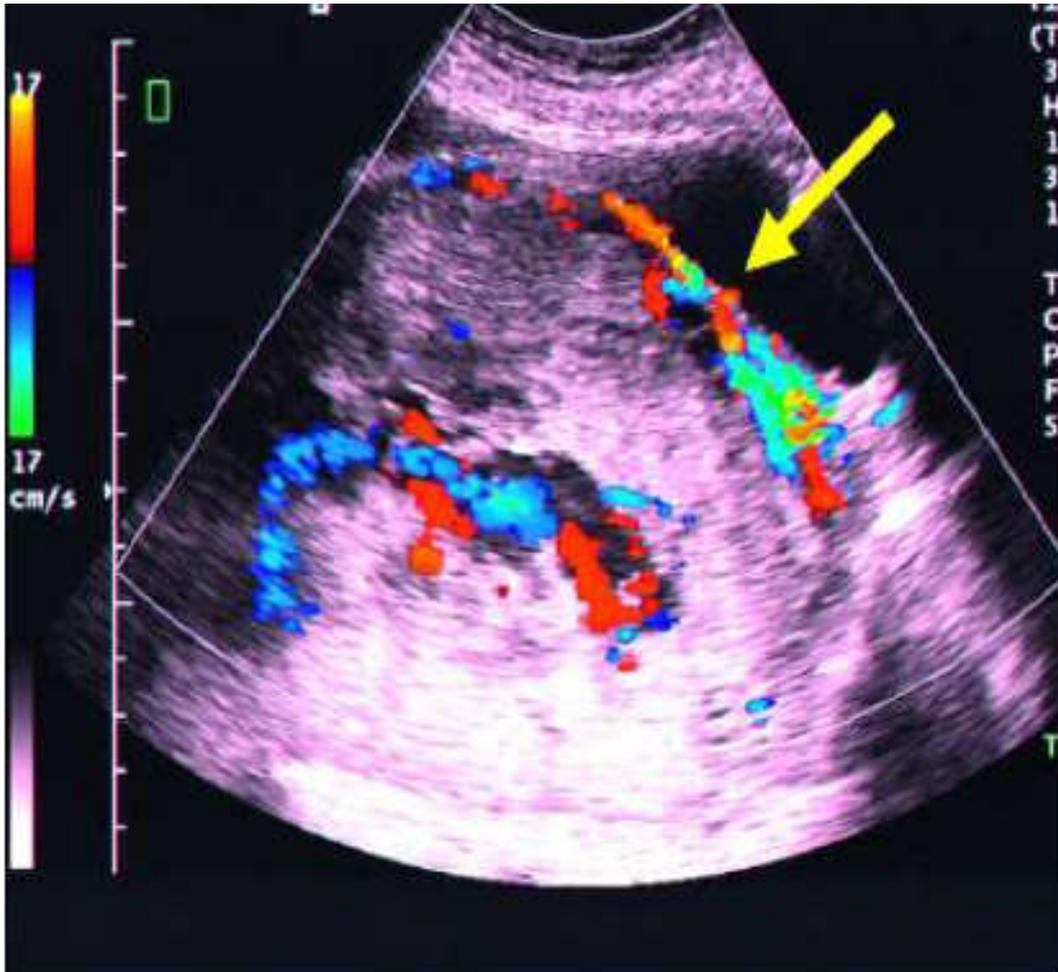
Transvaginal ultrasound at 33 weeks of gestational age: placenta previa complete.<sup>(56)</sup>
